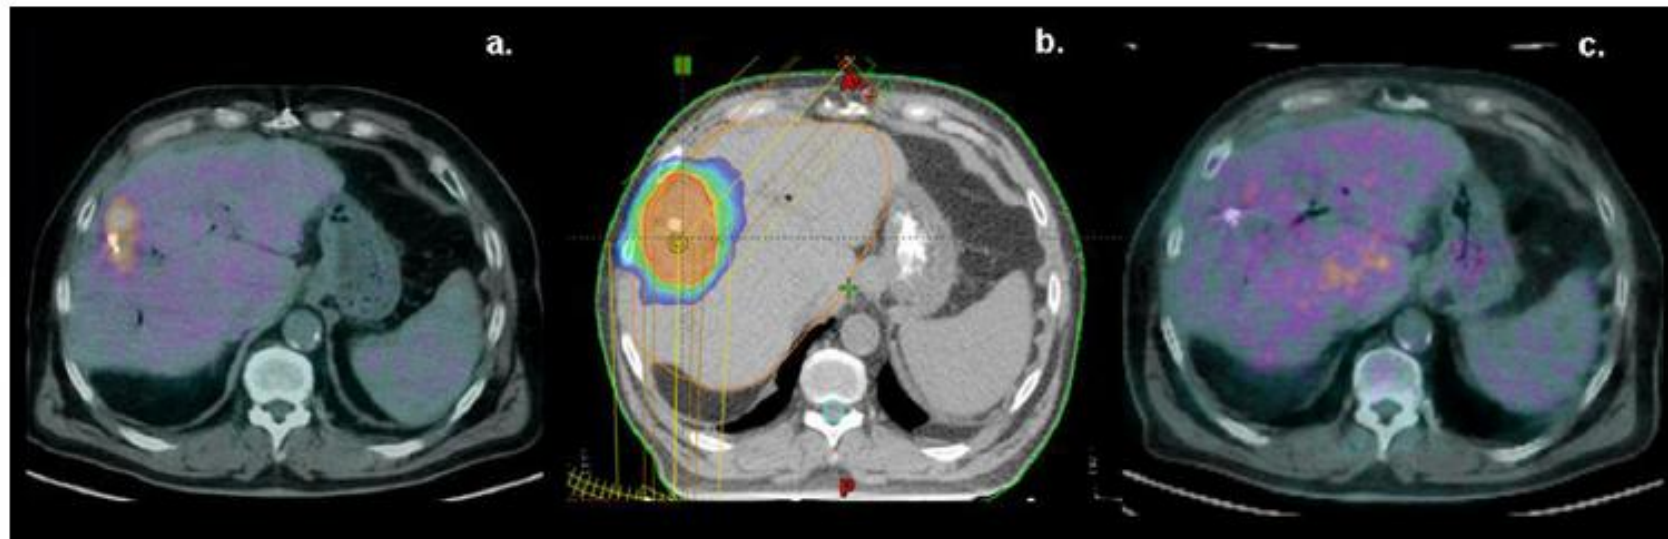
Patient treated with stereotactic body radiation therapy for recurrence of liver metastasis after surgery. (a) Positron emission tomography (PET)–computed tomography (CT) pretreatment image showing the lesion in the region of the surgical bed, defined by metal surgical clips. (b) Visualization of dose distribution on the planning target volume. (c) PET-CT image at 3 months after radiation therapy, showing complete metabolic response.
